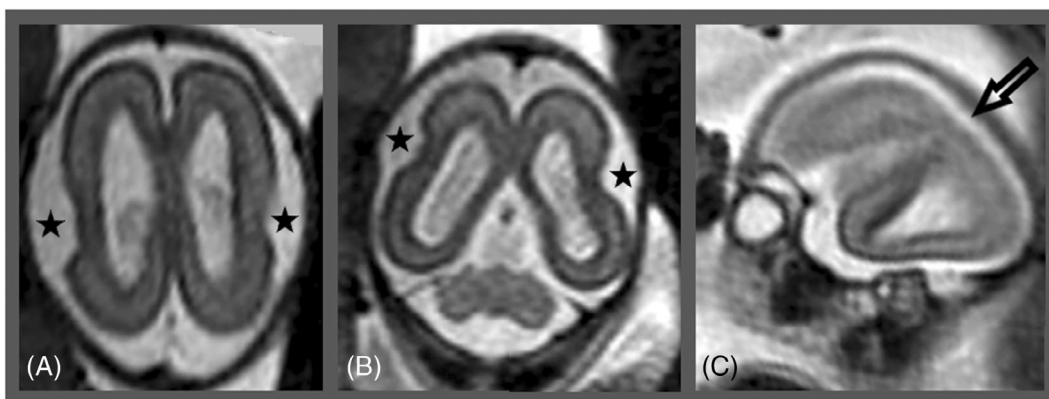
Perisylvian polymicrogyria at 21 GW. (A) axial and (B) coronal T2-weighted images show abnormal shape of the Sylvian fissures with abrupt angulations (stars); (C) sagittal T2-weighted image shows continuity between the Sylvian fissure and a convexity sulcus (arrow)
